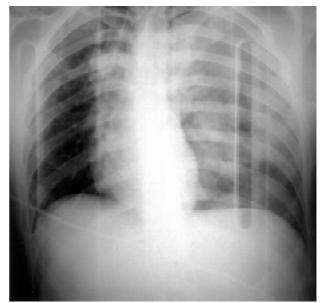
Chest radiograph showing a widening mediastinum and left lung contusion.
